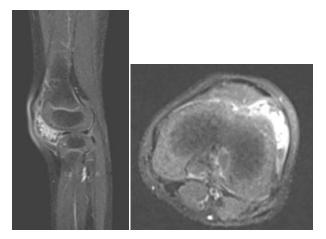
Sagittal and coronal T2-weighted MR image showing a heterogenous mass hyper intense lesion in the anterolateral aspect of the left knee joint with post contrast non-homogenous enhancement.
